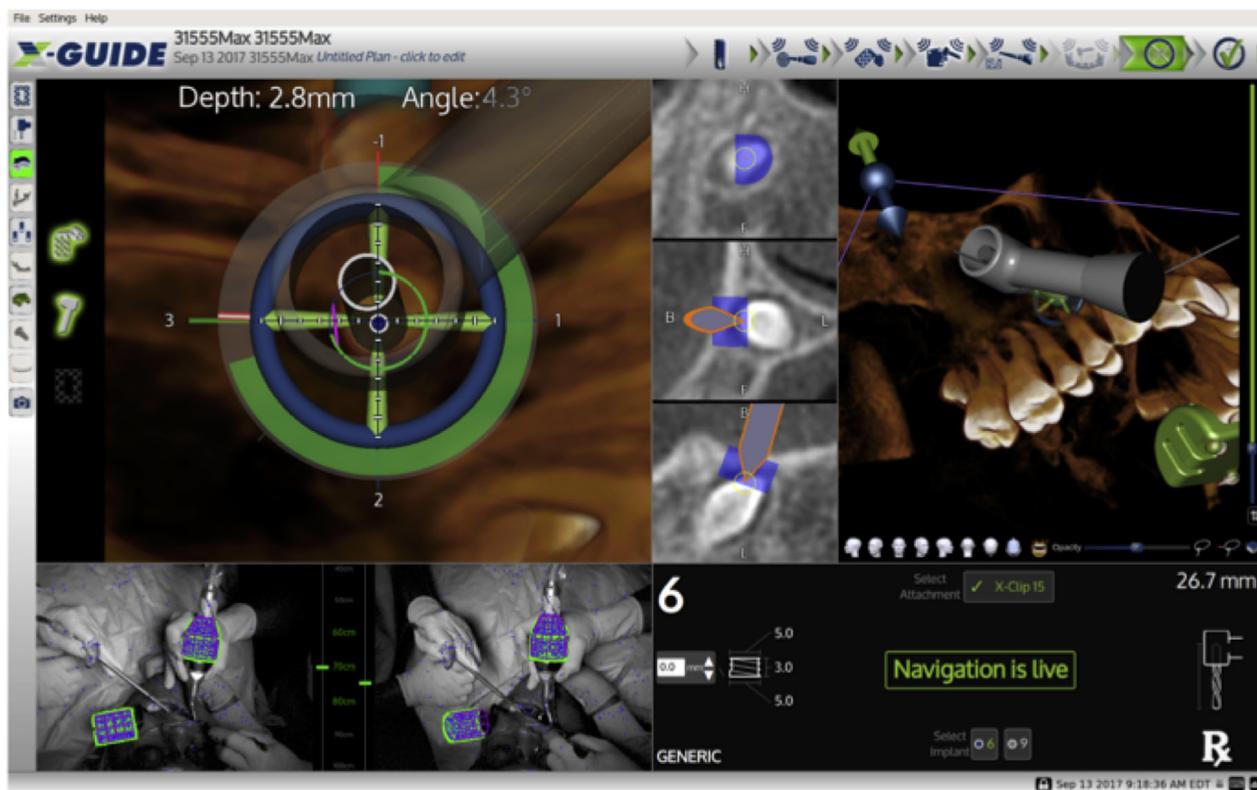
Intraoperative use of dynamic navigation to remove impacted supernumerary teeth supernumerary maxillary right second premolar and supernumerary maxillary left central incisor. Optical triangulation and fiducial registration related the position of the handpiece to cone-beam computed tomography anatomy in real time (lower left panels). This allowed the surgeon to guide the access osteotomies for teeth supernumerary maxillary right second premolar and supernumerary maxillary left central incisor after planning virtual implants at these sites (upper panels).
